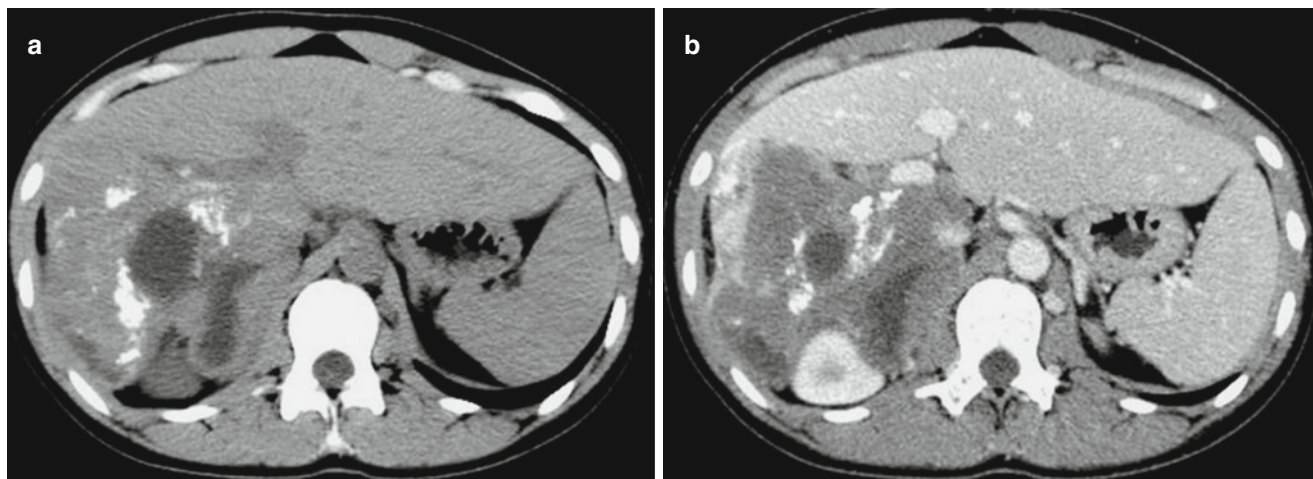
Hepatic alveolar hydatidosis. (a) Plain CT scanning demonstrates low-density lesion with irregular shape and poorly defined boundary in the right liver lobe. In the lesion, multiple calcification
